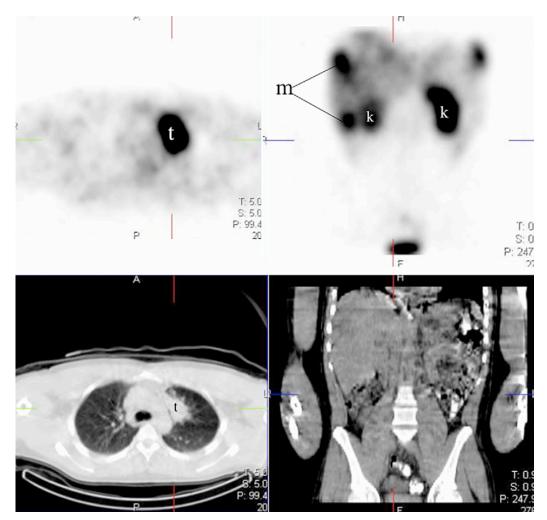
SPECT/CT Octreoscan images from a patient with primary pulmonary carcinoid tumor metastatic to the liver. Note the liver metastases are not discernible on the noncontrast CT. k, kidneys; m, liver metastases; t, lung carcinoid tumor.
